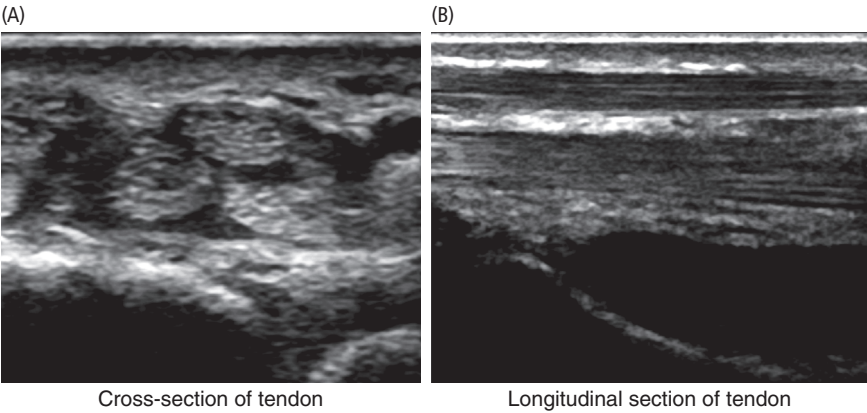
Ultrasound appearance of tendon – fibrillar pattern
